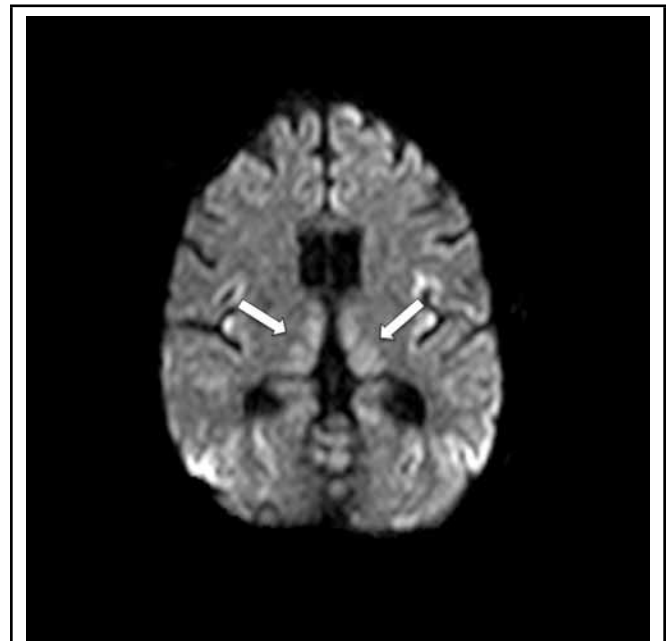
MRI Diffusion-weighted images showed mildly restricted diffusion in the thalami.
